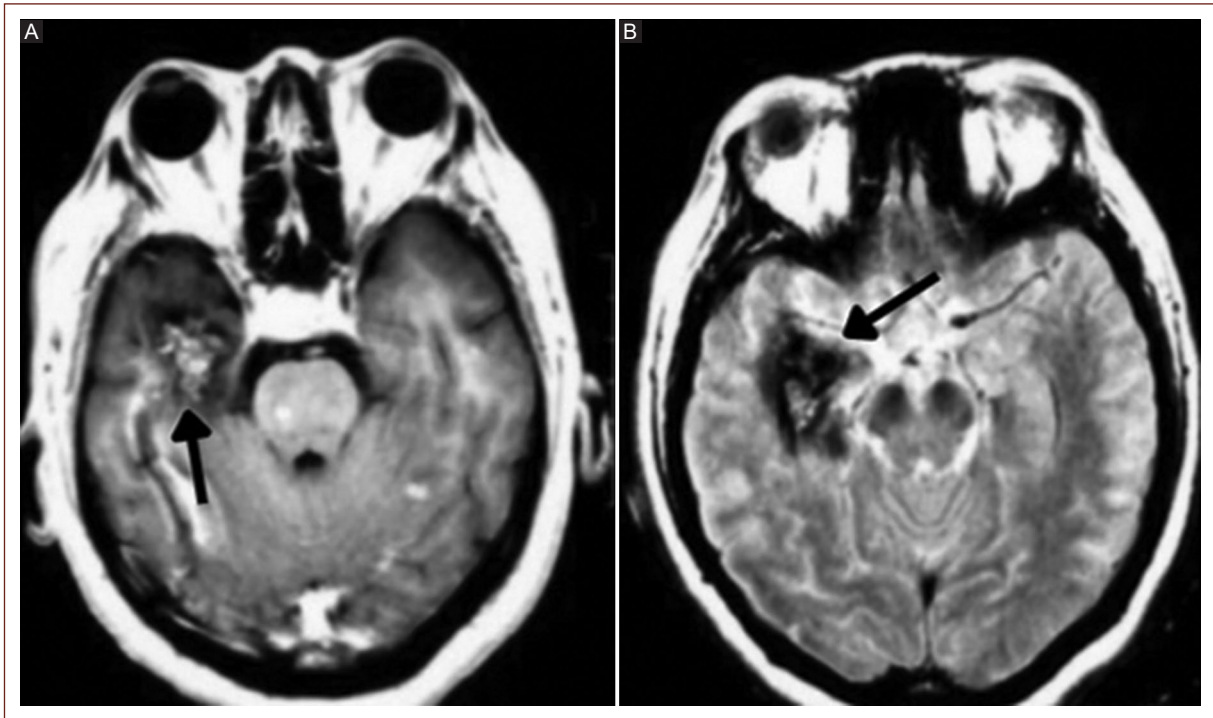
Cerebral magnetic resonance imaging. A and B: cerebral metastases are shown in the right temporal lobe.
